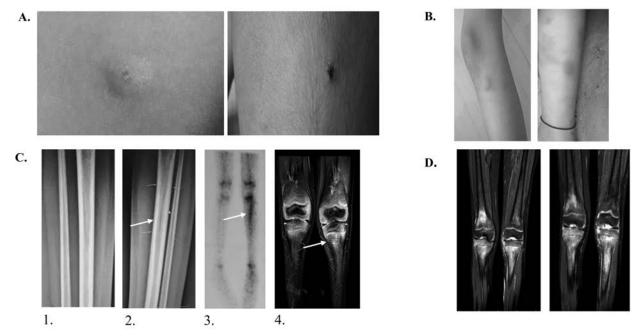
Skin manifestations and radiological images demonstrating importance of different imaging techniques in patients with CRMO. (A) Pustular skin lesions on right leg and back (Patient 1). (B) Erythema nodosum in bilateral lower limbs (Patient 4). (C) 1. Normal comparative right tibial radiograph; 2. Subtle periosteal thickening on the left tibia (can be easily missed); 3. Delayed phase bone scan demonstrating discrete increased uptake along left proximal tibial metadiaphysis; and 4. Coronal STIR MRI image demonstrating left proximal tibial signal hyperintensity (Patient 1). (D) Coronal STIR MRI images of bilateral knee demonstrating right distal femoral and bilateral proximal tibial edema. There is transphyseal edema in the proximal tibia (note: this is not seen in distal femur) and this could predispose to growth disturbances (Patient 3). CRMO: chronic recurrent multifocal osteomyelitis; MRI: magnetic resonance imaging; STIR: short-tau inversion recovery.
